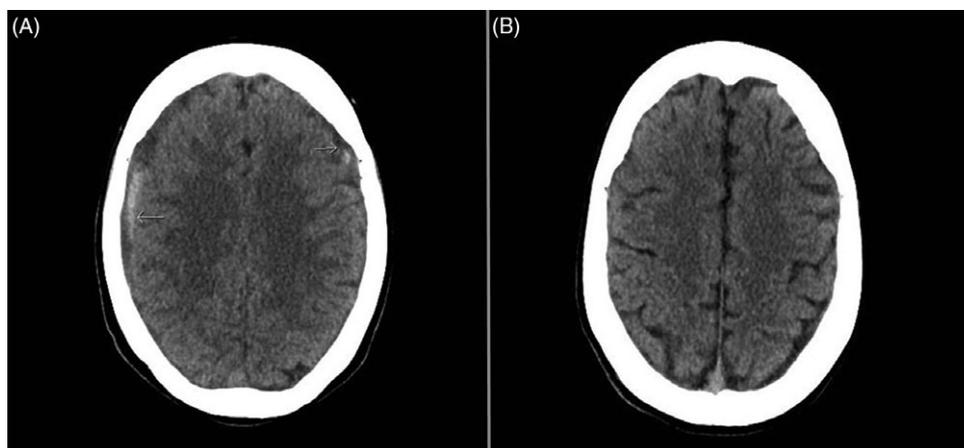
(A) Initial bilateral SDHs on head CT showing acute (arrows) on chronic collections. They measured maximally 6 mm on the right and 3 mm on the left. (B) Shows resolution of the collections 2 months after epidural blood patch.
